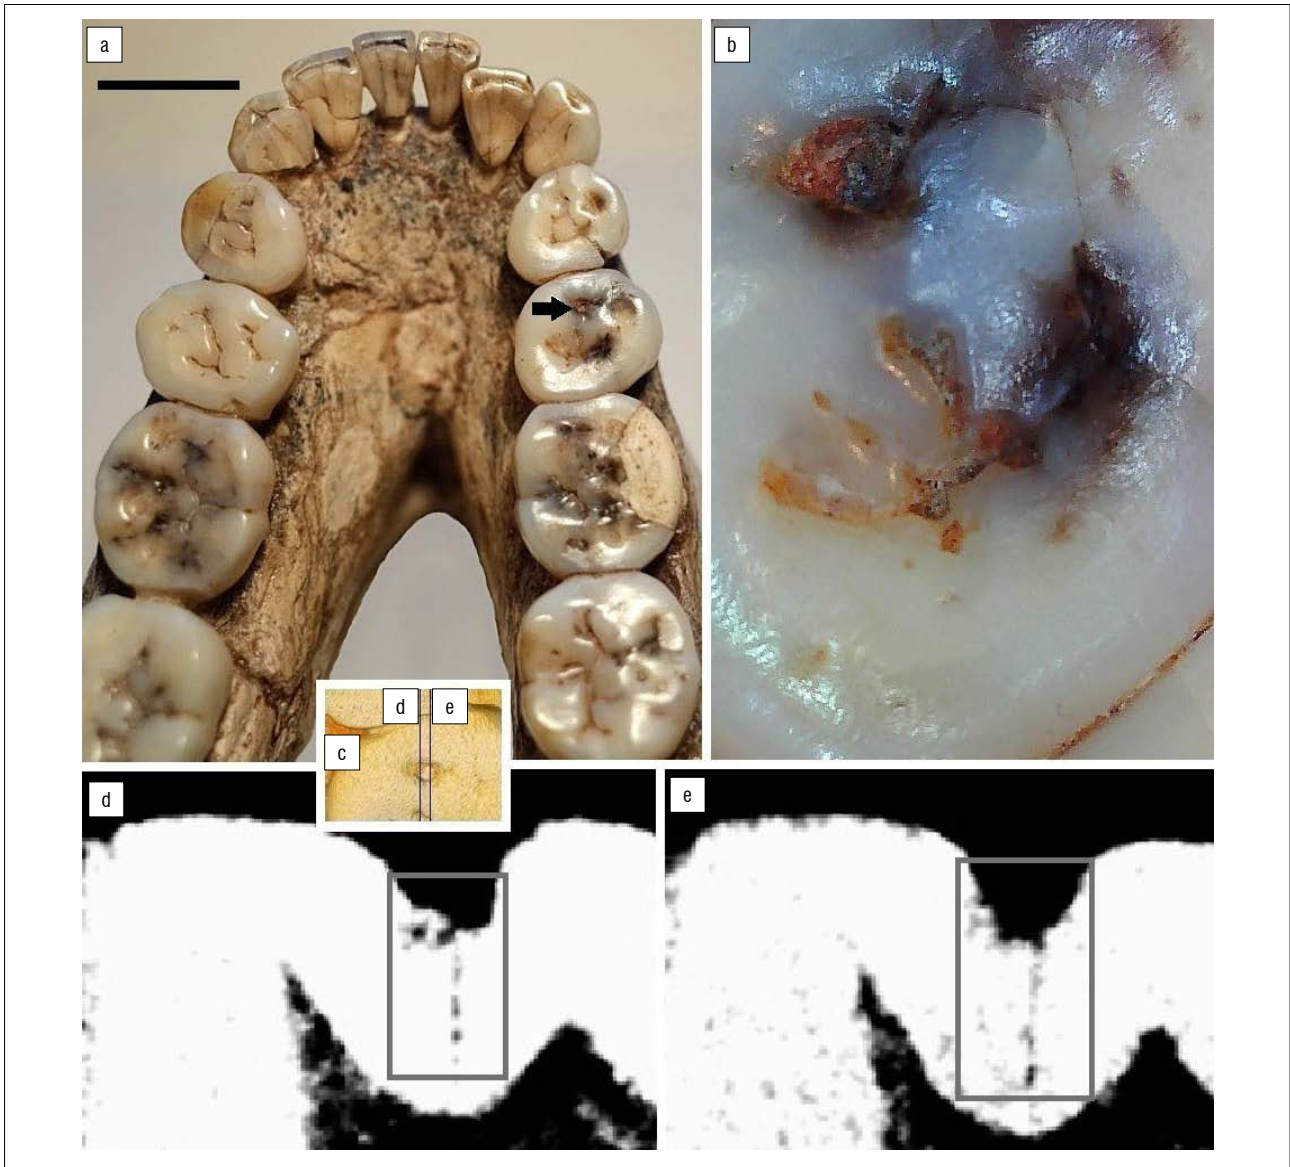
SK 23 (*Paranthropus robustus*). (a) Occlusal view of mandible, with the lesion on the right second premolar highlighted (black arrow). (b) Close-up of the occlusal surface of the right second premolar. (c) CT reconstruction with the position of the two slices highlighted. (d) CT slice toward the lingual part of the cavity. (e) CT slice toward the buccal portion of the cavity.
